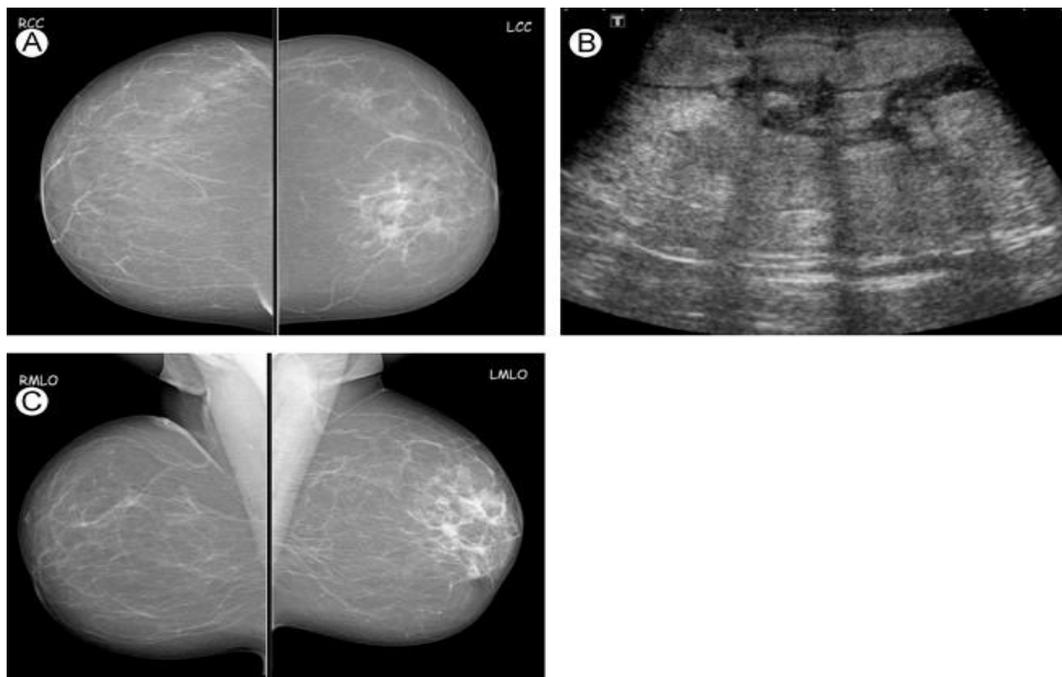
1. Ultrasonography of breast.
